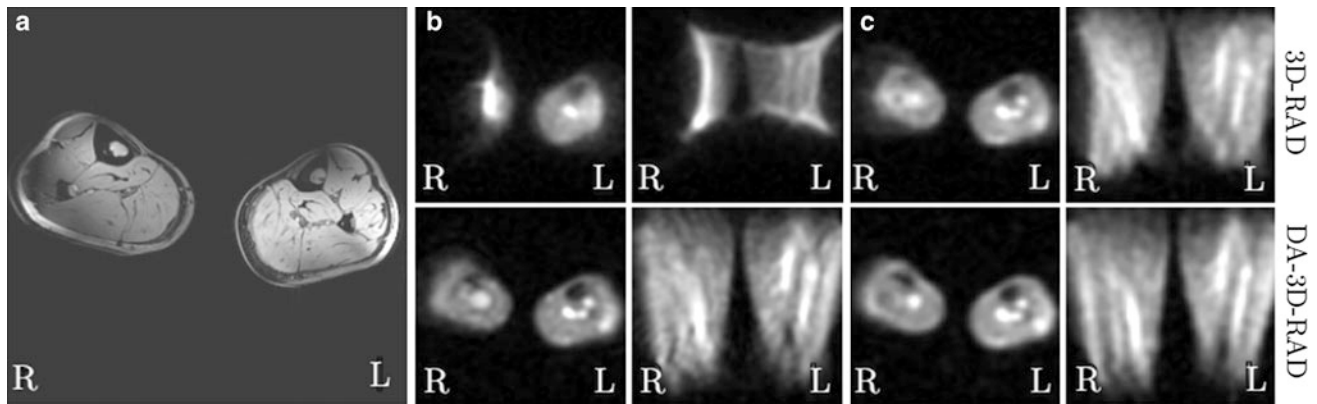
Images of the calf muscles from a healthy volunteer ($B_0 = 7$ T). This is a worst-case scenario, where a bad B_0 -homogeneity in the area of the right lower leg leads to severe image artifacts in ^{23}Na MRI. a ^1H MRI yields acceptable image quality, except for chemical shift artifacts and signal variations due to B_1 -inhomogeneities. b, c Conventional
